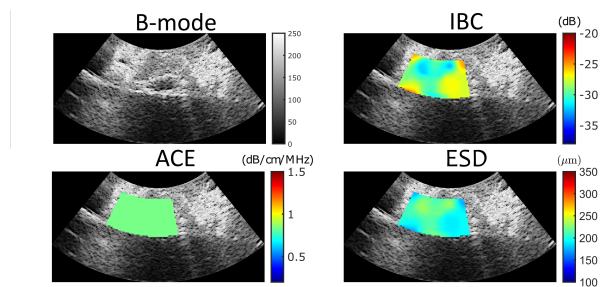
ACE, IBC and ESD maps overlaid on ultrasound B-mode image for an example placenta.
